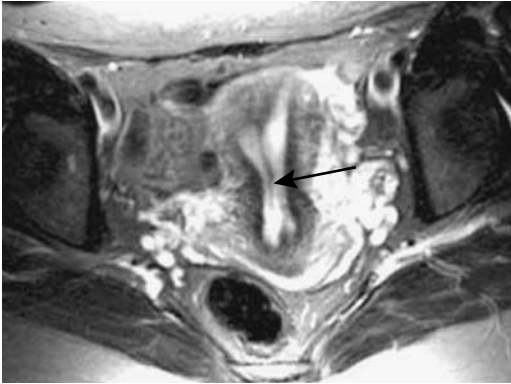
Septate uterus. Transverse T2-weighted image identifies a septum in the uterine cavity (arrow). The external uterine outline is normal. (Source: Imaoka I, Kitagaki H, Sugimura K. MR imaging associated with female infertility. *Nichi-Doku Iho* 2000;45:440–450, with permission from Nihon Schering K. K.)
